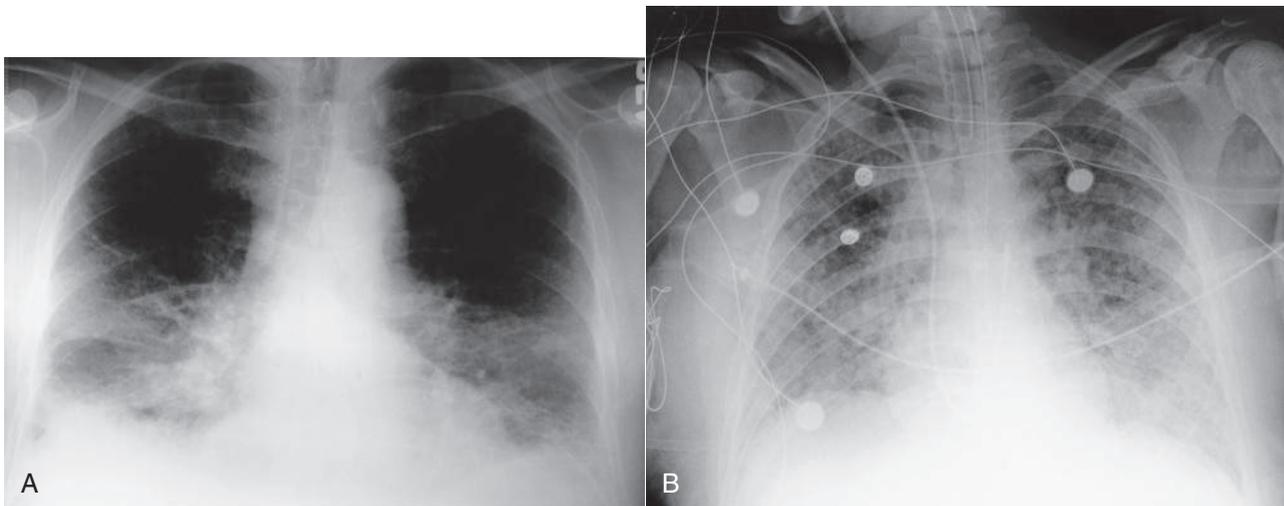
Chest radiographs show typical radiographic features of congestive heart failure (CHF) and acute respiratory distress syndrome (ARDS). A, CHF is characterized by cardiomegaly, interstitial infiltrates, bilateral perihilar and basilar alveolar infiltrates, and bilateral pleural effusions, which cause blunting of the costophrenic angles. B, ARDS is commonly associated with normal cardiac size, diffuse peripheral alveolar infiltrates, and minimal or absent pleural effusions.
